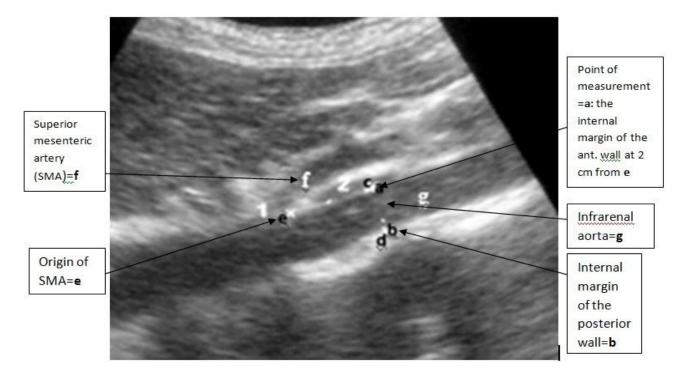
2D grayscale ultrasound longitudinal image of the abdominal aorta showing the pattern of measurement. a = point of measurement of AAD (inner margin of the anterior wall),b = Inner margin of the posterior wall, c = outer margin of anterior wall, d = outer margin of posterior wall, e = origin of superior mesenteric artery, f = superior mesenteric artery, g = infrarenal aorta.
